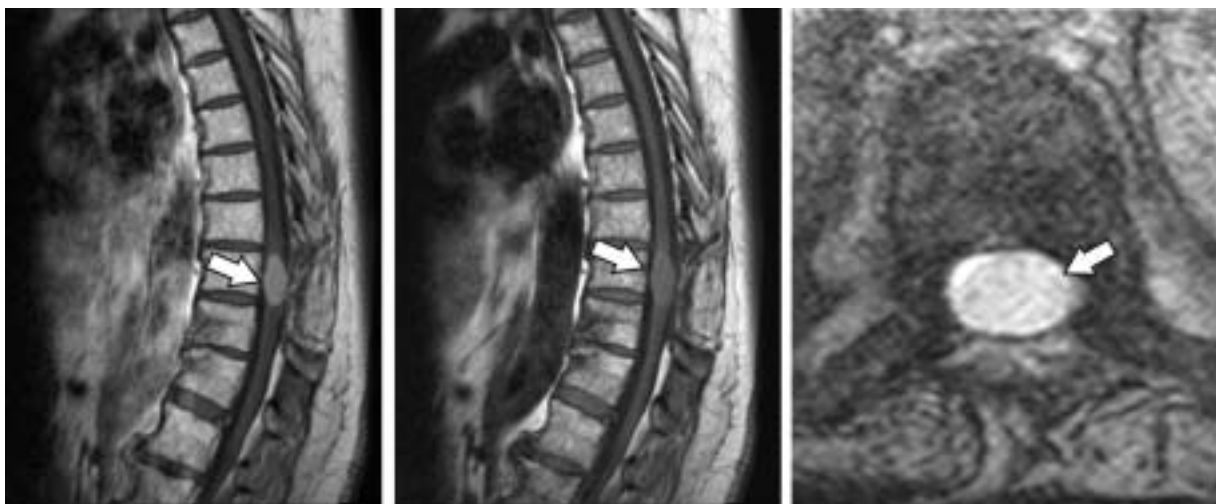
Follow up MRI examination 12 months after surgery. Intramedullary tumor is present in previous location (arrow).
